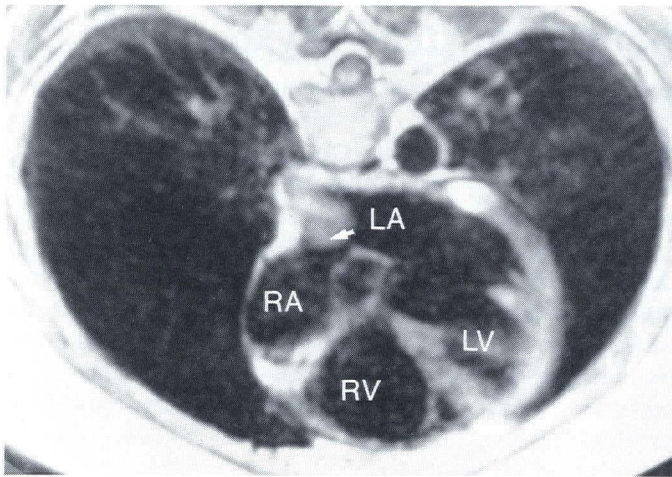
(Case 1)—Magnetic resonance imaging demonstrating the mass attached to the interatrial septum (arrow). (LA = left atrium, LV = left ventricle, RA = right atrium, RV = right ventricle.)
